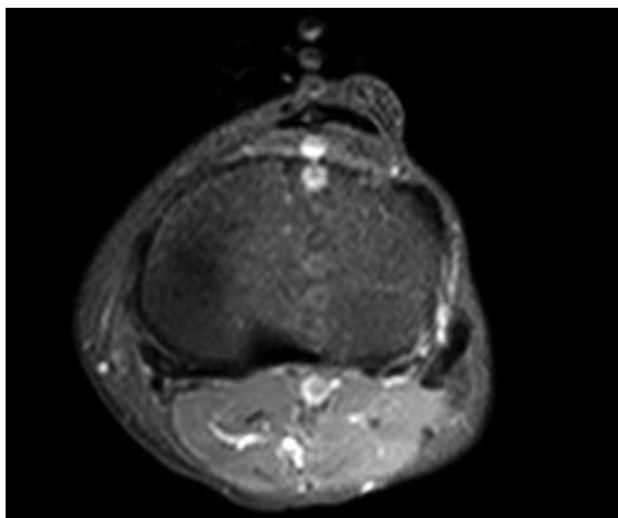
Axial T1-weighted post-contrast image of the knee with fat saturation showing ghosting artifact of the popliteal artery along the phase-encoding direction due to pulsation.
